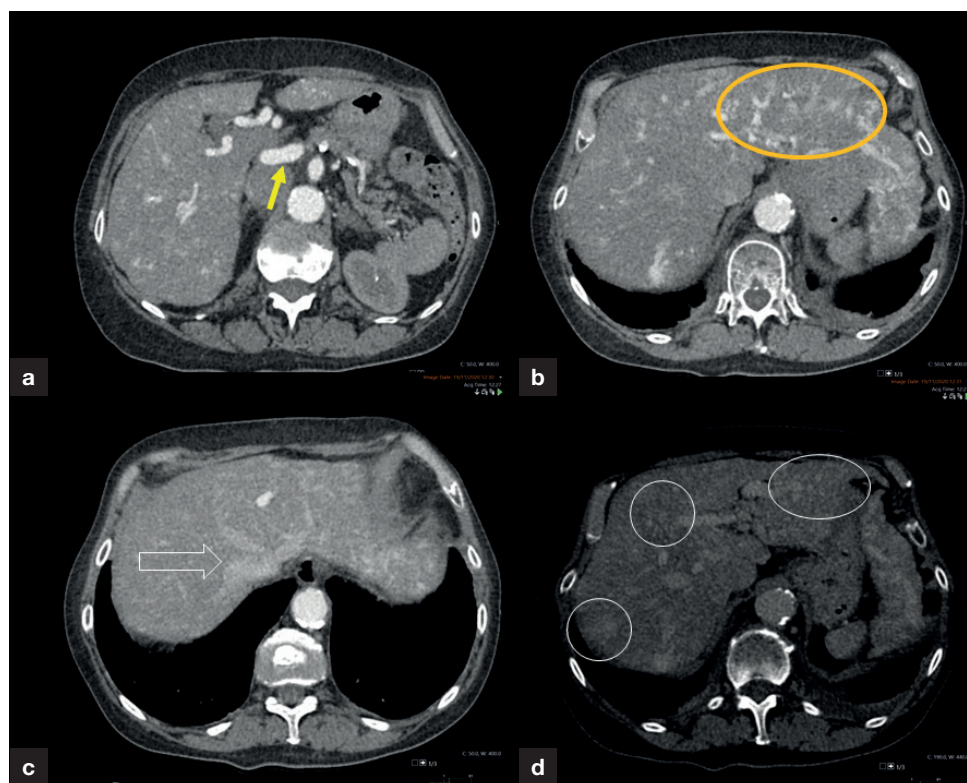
Axial computed tomography images. a. Arterial phase image showed a large common hepatic artery and its main branches (yellow arrow), also note the absence of contrast in the portal vein which lies between the artery branches. b. Arterial phase image showing numerous tortuous arterial branch vessels in the left lobe of liver (orange circle). c. Arterial phase image showing contrast in hepatic veins (white arrowhead) despite no contrast in portal vein, confirming arterio-venous shunting. d. Portal venous phase study shows multiple foci of persistent enhancement in the liver parenchyma (white circles), suggestive of venous malformations in the clinical context.
